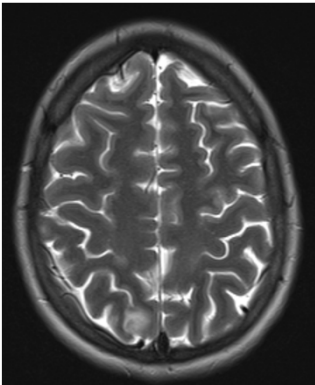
T2 weighted MRI image Figure 2: FLAIR sequence MRI image
